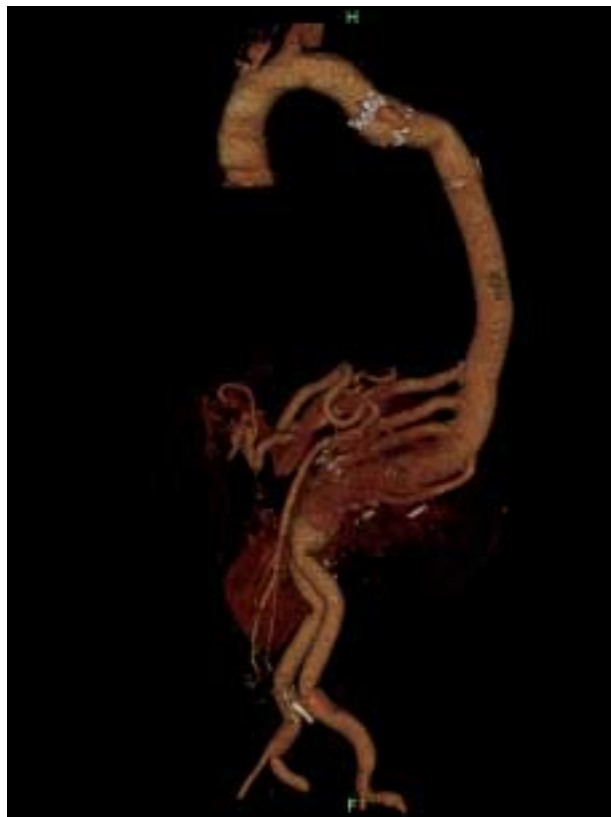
3D reconstruction of the contrast CT scan performed after open thoracoabdominal repair. The celiac, superior mesenteric artery, and both renal arteries have been reimplanted and the proximal anastomosis of the thoracic graft has been supported with a 26-mm X 33-mm Excluder stent graft. There is excellent flow in all visceral segments.
